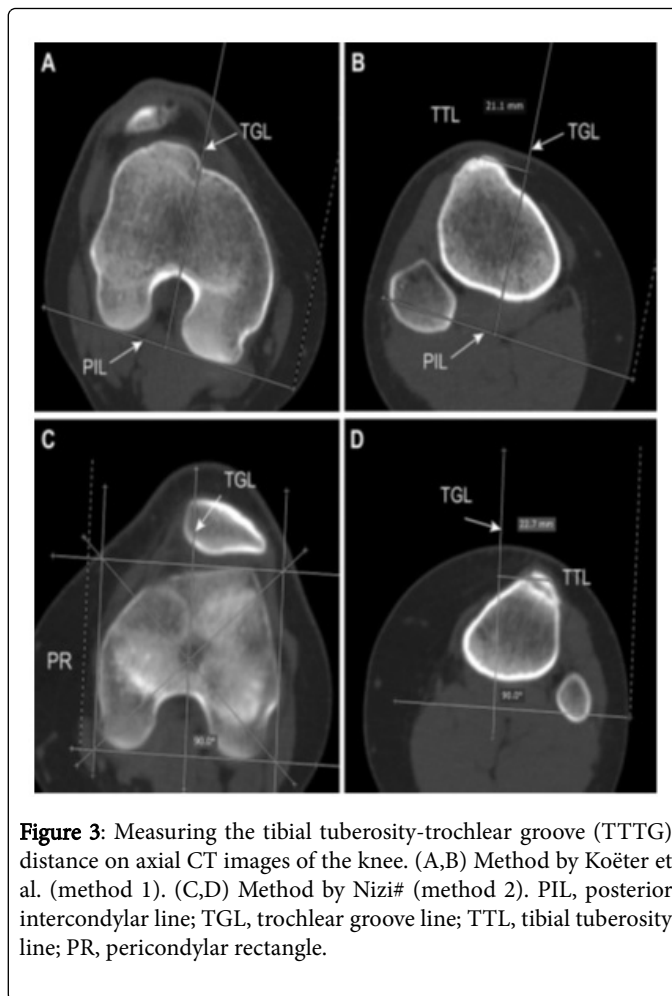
Measuring the tibial tuberosity-trochlear groove (TTTG) distance on axial CT images of the knee. (A,B) Method by Koeter et al. (method 1). (C,D) Method by Nizi# (method 2). PIL, posterior intercondylar line; TGL, trochlear groove line; TTL, tibial tuberosity line; PR, pericondylar rectangle.
